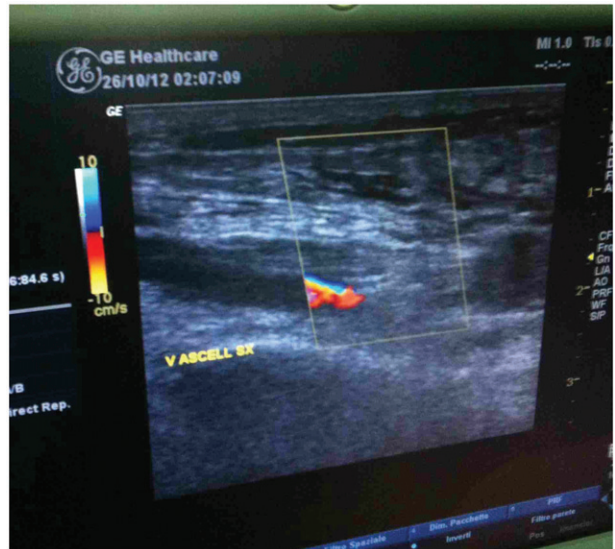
Color Doppler ultrasound scan showing a deep vein thrombosis in the left axillary vein.
